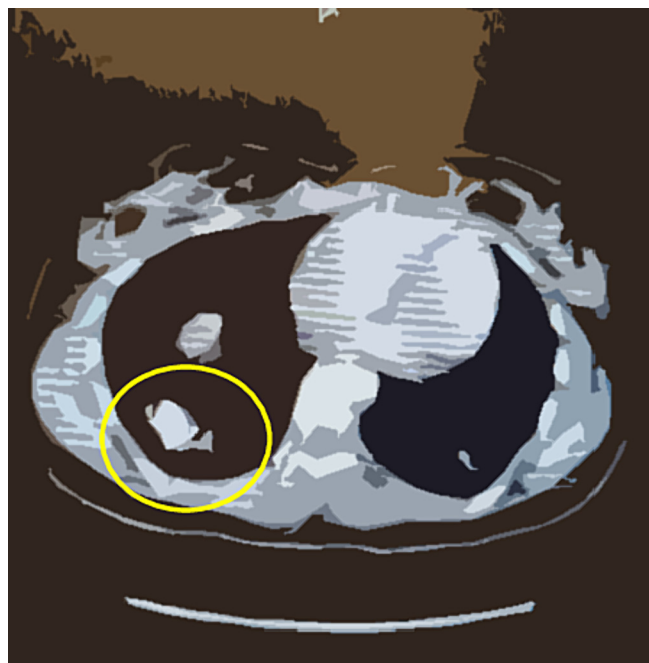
Chest CTA Right lower lobe AVM.
